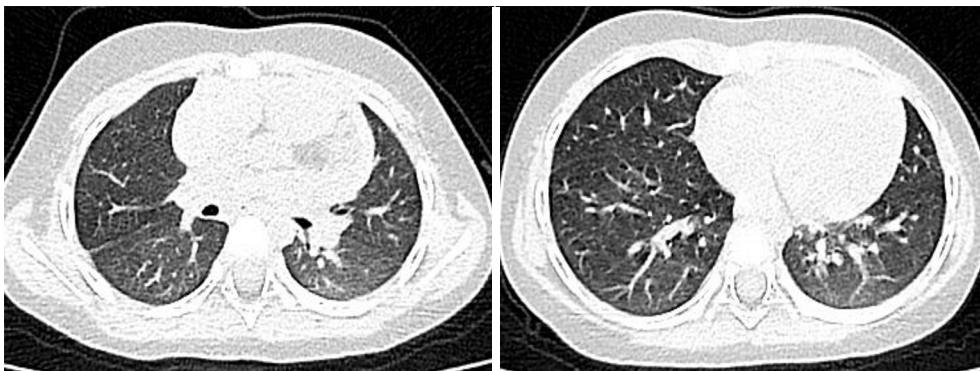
Case 6, a 2 years old girl, no abnormality on chest CT.
